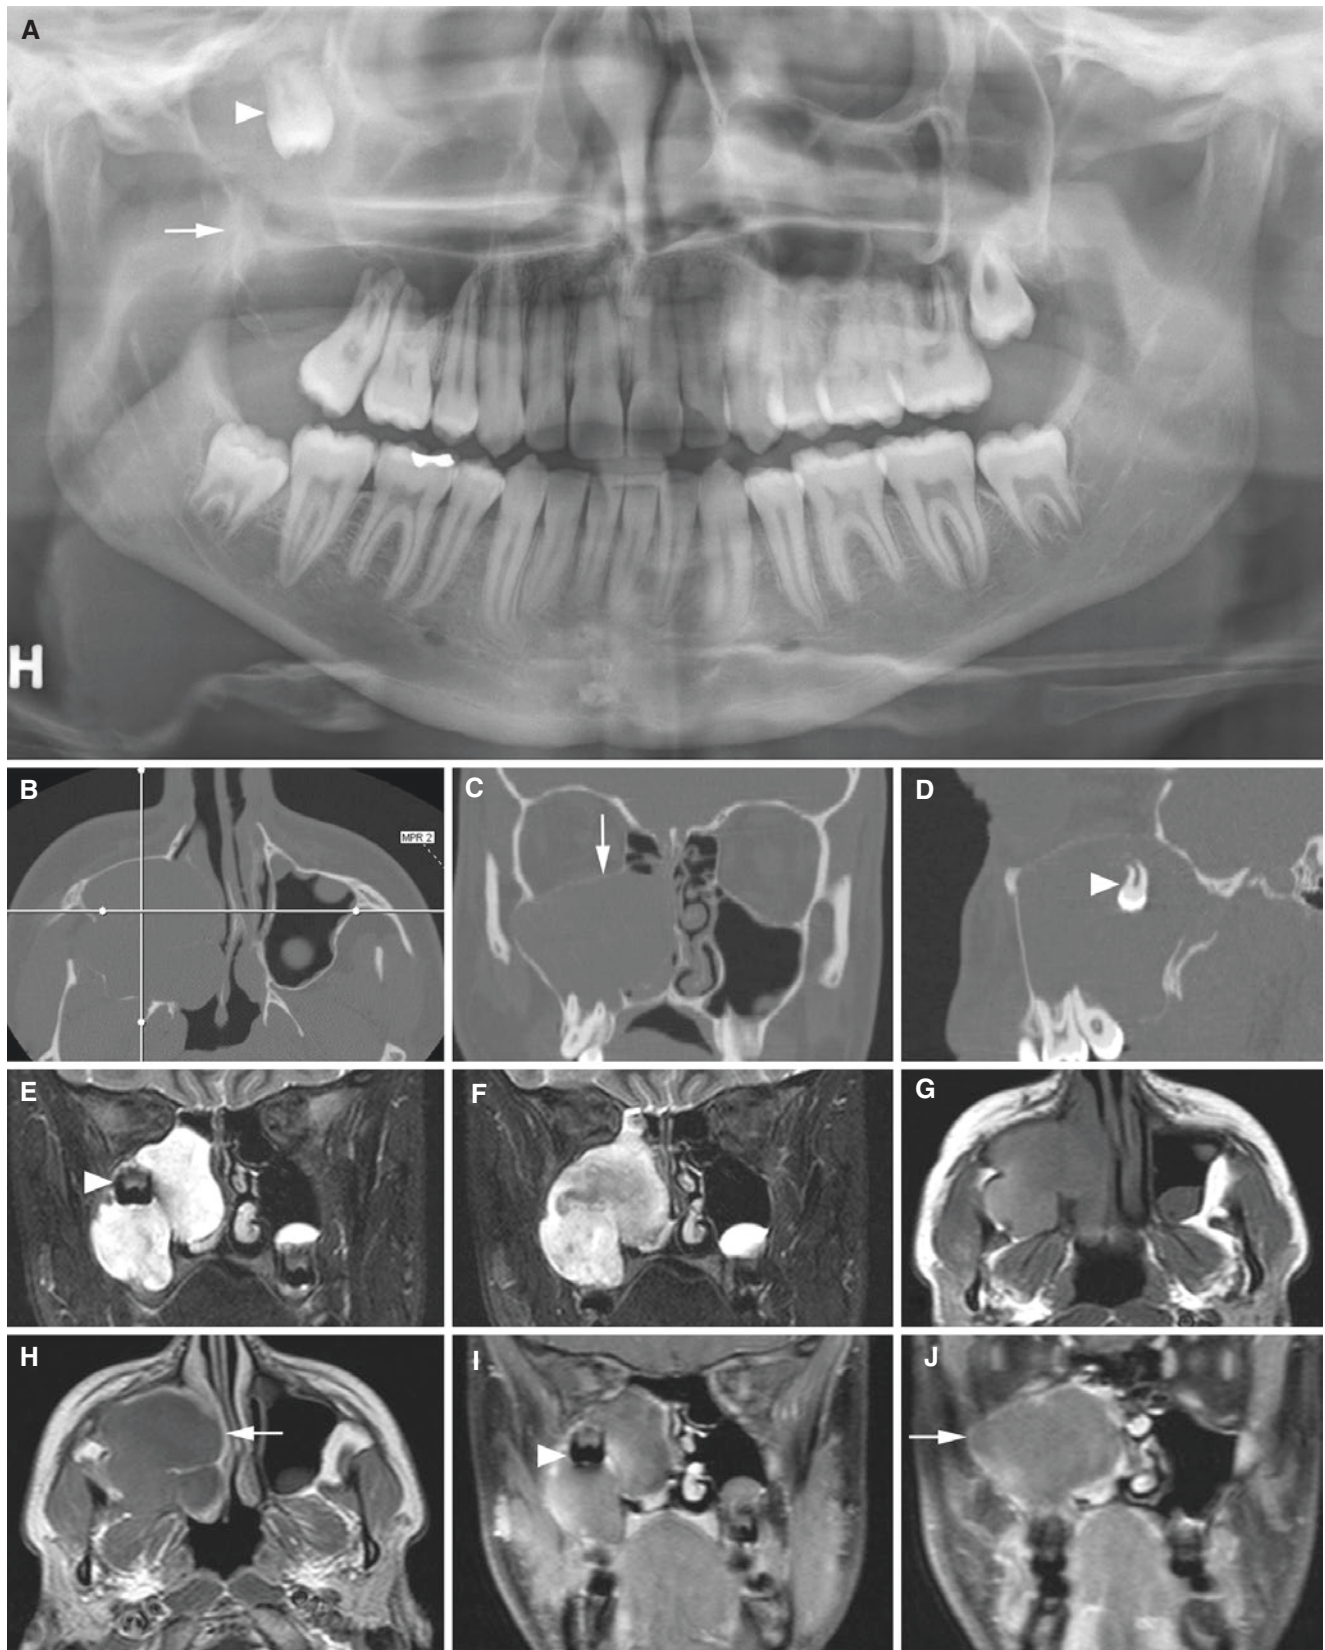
Keratocystic odontogenic tumor, maxillary sinus/maxilla; 16-year-old male with variable sinus symptoms. (A) Panoramic view shows radiolucency in right maxilla (arrow) and displaced tooth (arrowhead). (B) Axial (with cursor lines), (C) coronal, and (D) sagittal CT images show expanding maxillary sinus with partially corticated outline (arrow) and impacted wisdom tooth (arrowhead). (E, F)
